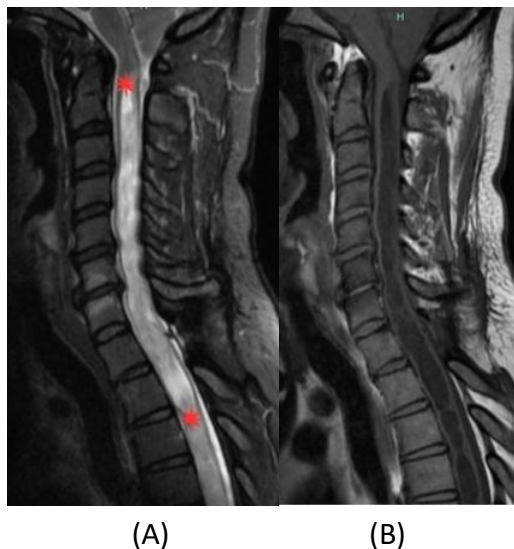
Sagittal MRI of the cervical and upper thoracic spine. (A) T2-weighted image demonstrates a prominent, hyperintense intramedullary syrinx extending from the C2 to the T2 vertebral levels (delineated by red asterisks). (B) The T1-weighted image shows the corresponding hypointense signal within the spinal cord, confirming the presence of an extensive fluid-filled cavity consistent with syringomyelia
